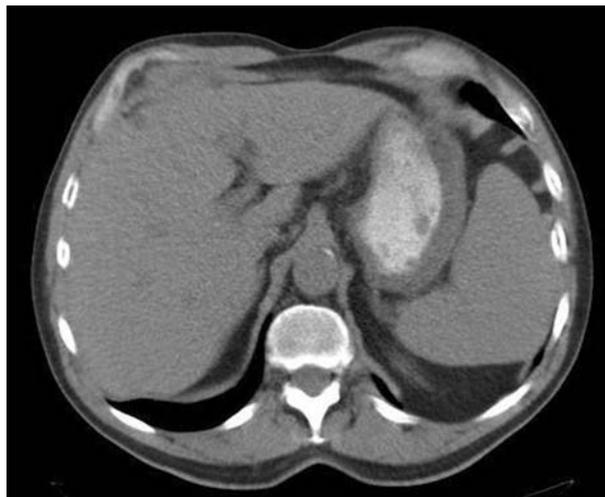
CT abdomen of the patient revealing splenomegaly.
